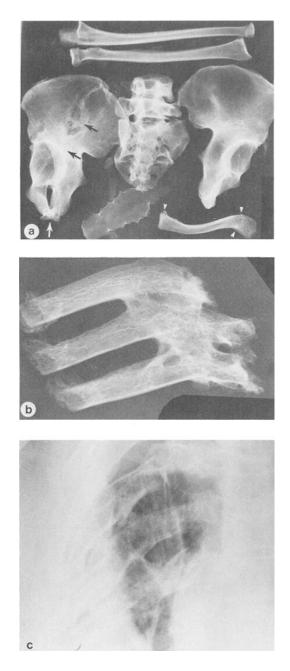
Case 6: (a) This photograph is representative of films of skeletal remains presented for interpretation. The image includes a radius, ulna, clavicle, sternum, sacrum, the last two lumbar vertebrae, and both innominate bones. The innominate bone on the left has a healed fracture through the iliac wing, the acetabulum, and the ischium (arrows). Both innominate bones have narrow sciatic notches, a characteristic of males. The three tiny spurs arising from the distal clavicle (arrowheads) were identified in a premortem clinical chest film and thus were additional unique skeletal features for scientific confirmation of identity. (b) Detail of rib fragments from the skeleton shows portions of three ribs fused together after previous fractures. (c) Close-up photograph of a region from a premortem clinical chest film shows the same three fused ribs, one of many unique similarities between premortem radiographs and postmortem films of the skeleton.
